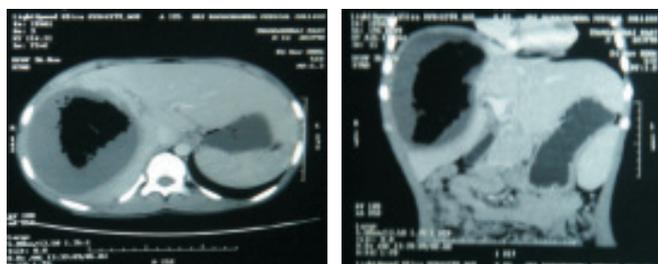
CT done six weeks later shows the complete necrosis of the lesion
